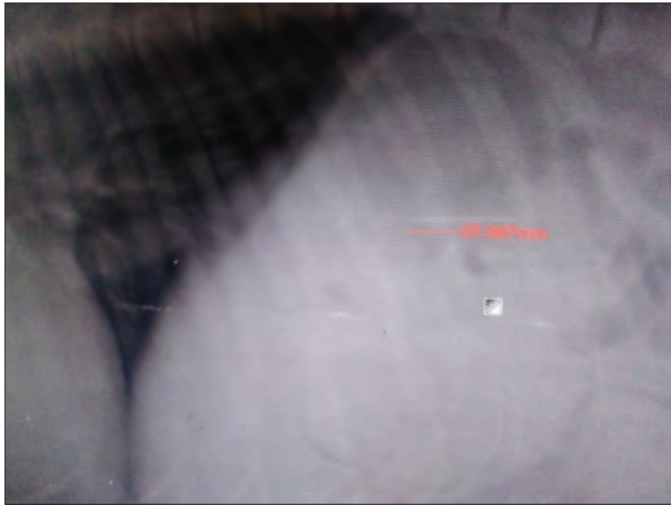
Radiographic image showing the presence of linear potential foreign body in stomach
